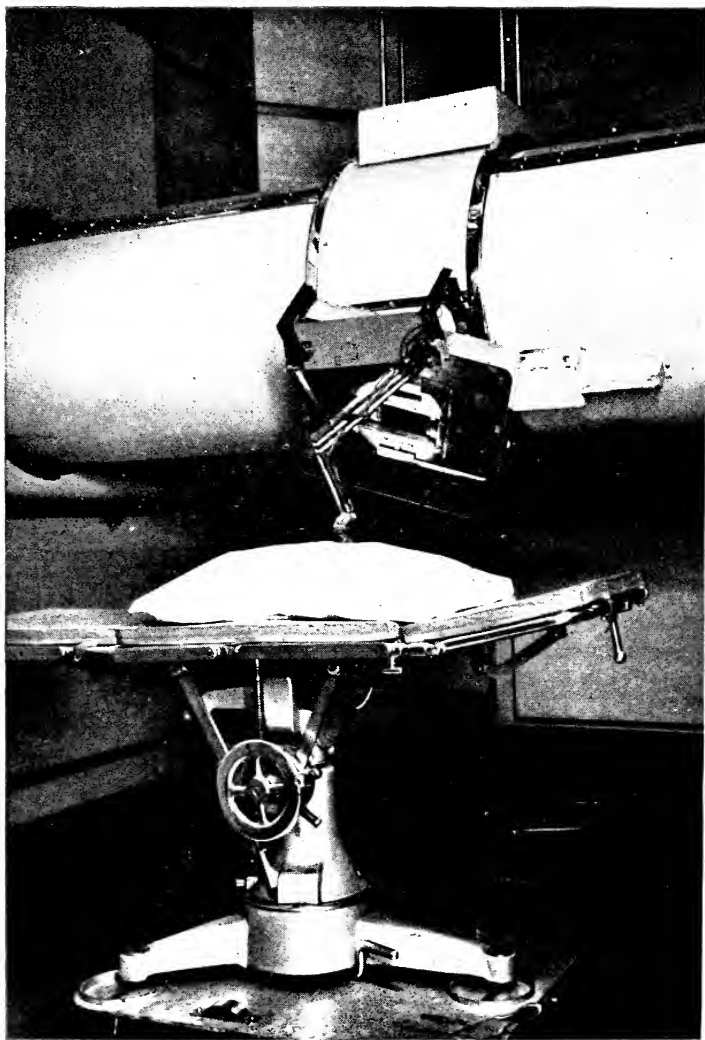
MILLION-VOLT X-RAY TUBE
